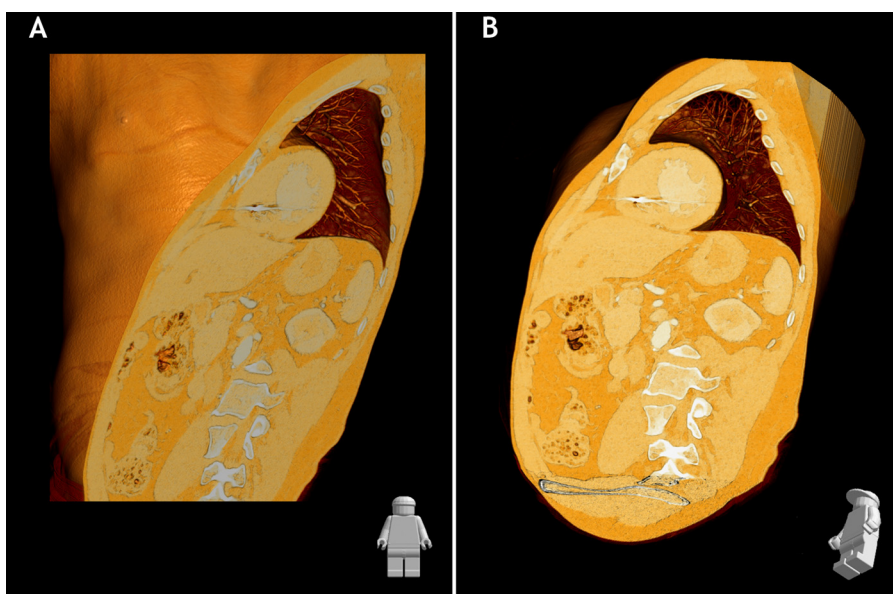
Volume rendering technique computed tomography images of the chest. (A) Anterior view of the thorax in the coronal plane in which the thorax is transected in the short-axis (SA) plane perpendicular to the cardiac long axis. This long-axis of the heart is defined by the line between the apex and the center of the mitral valve plane (D) by means of angulation the short-axis view of the heart is generated.
